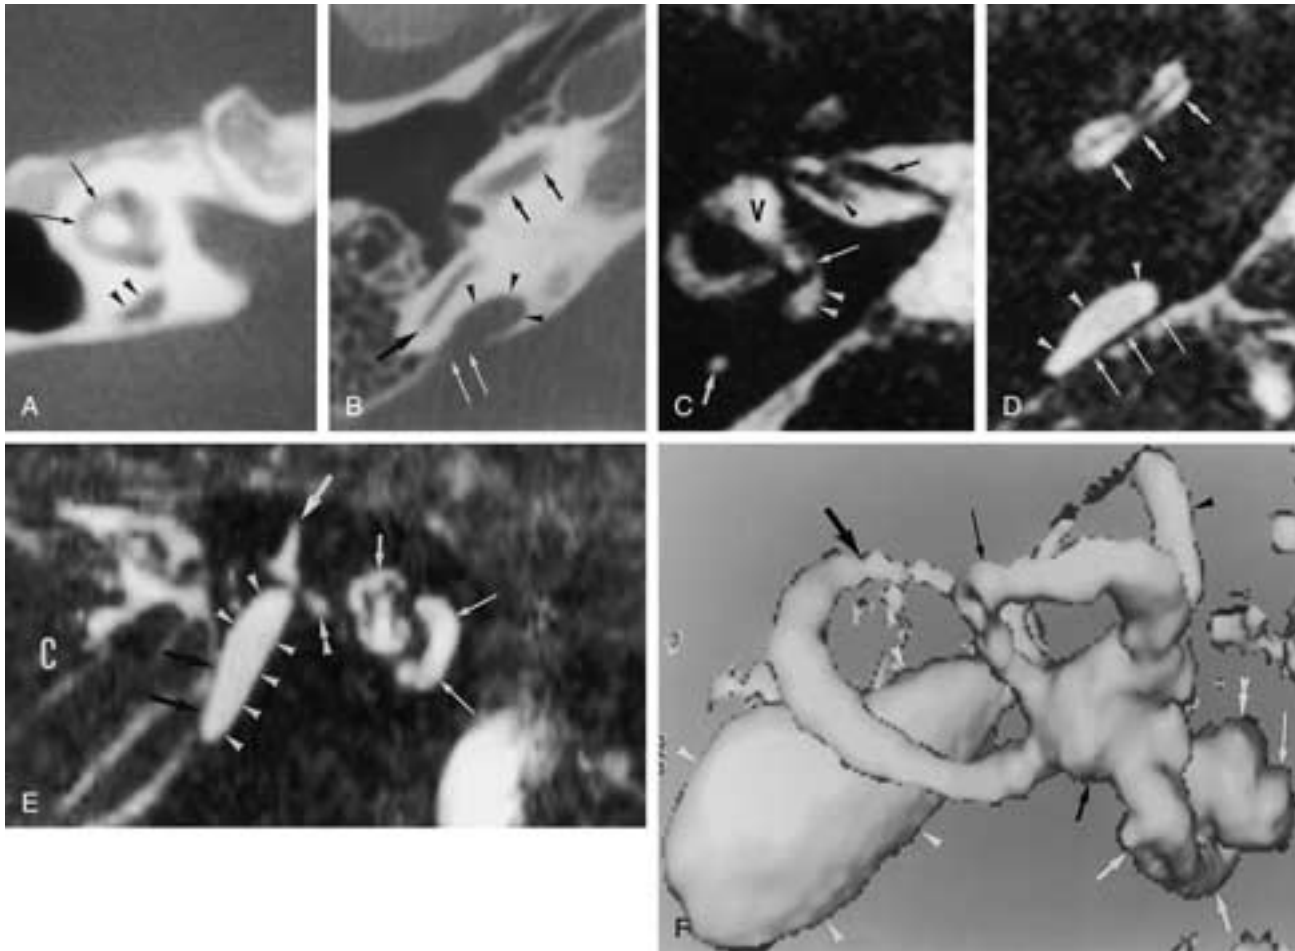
Large vestibular aqueduct/duct and sac. A, Axial CT image at the level of the right lateral semicircular canal. The diameter of the vestibular aqueduct is more than 1.5 mm (*black arrowheads*) and is therefore enlarged. Normal lateral semicircular canal (*long black arrows*). Normally, the diameter of the vestibular aqueduct never exceeds the diameter of the semicircular canals. B, Axial CT image at the level of the basal turn of the right cochlea. The enlarged vestibular aqueduct (*black arrowheads*) opens in the posterior fossa, but the sac inside the aqueduct cannot be distinguished from the posterior fossa structures (*long white arrows*). Normal posterior semicircular canal (*large black arrow*) and basal turn of the cochlea (*small black arrows*). C, Axial T2-weighted gradient-echo image through the right endolymphatic duct. The connection (*long white arrow*) between the enlarged endolymphatic duct (*white arrowheads*) and the vestibule (*V*) can be recognized. The endolymphatic duct is enlarged, as its diameter is more than 1.5 mm or because it is larger than the diameter of the posterior semicircular canal (*small white arrow*). Facial nerve (*small black arrow*) and superior vestibular branch of the VCN (*black arrowhead*). D, Axial T2-weighted gradient-echo image through the enlarged endolymphatic sac. The large fluid-filled endolymphatic sac (*white arrowheads*) can be separated from the CSF in the posterior fossa because the dura mater between the two fluid-filled spaces can be depicted on MR imaging (*long white arrows*). Note that the signal intensity of the fluid inside the endolymphatic sac is higher than the signal intensity of the CSF. The lower signal intensity of CSF is caused by CSF flow. Normal basal turn of the cochlea (*small white arrows*). E, T2-weighted gradient-echo images, parasagittal reconstruction through the right inner ear and large endolymphatic duct and sac. The enlarged endolymphatic duct and sac (*white arrowheads*) can be followed from the labyrinth to the posterior fossa. The endolymphatic sac can be distinguished from the posterior fossa structures (*large black arrows*). Superior semicircular duct (*large white arrow*), vestibule (*double white arrowhead*), IAC (*small white arrow*), cochlea (*long white arrows*), cerebellum (*C*). F, Three-dimensional virtual image of the right inner ear, made by using 0.7 mm thick T2-weighted gradient-echo images. The large endolymphatic duct and sac can be visualized in their full extent on this image (*white arrowheads*). Normal lateral (*long black arrow*), superior (*black arrowhead*), and posterior (*large black arrow*) semicircular ducts; normal basal (*small white arrows*), second (*double white arrowhead*), and apical turns (*long white arrow*) of the cochlea; and normal vestibule (*small black arrow*).
